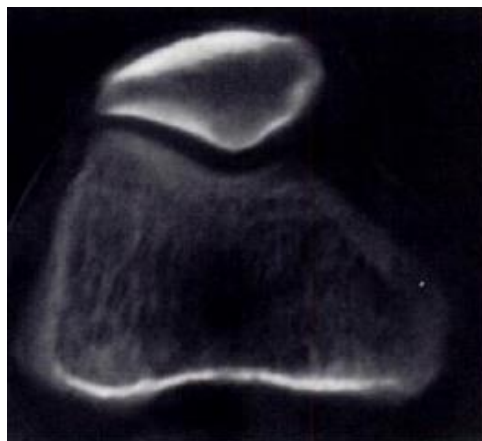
Computed tomography - lateral support of the kneecap [4].
